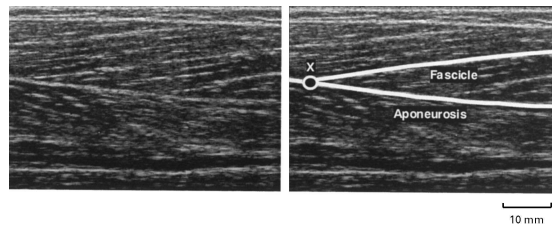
Longitudinal ultrasound image of the Tibialis Anterior (TA) [44]. The point X represents the selected point of attachment between the muscle fascicle and aponeurosis. The distance travelled by X over a range of images taken every 5° was measured with a ruler
